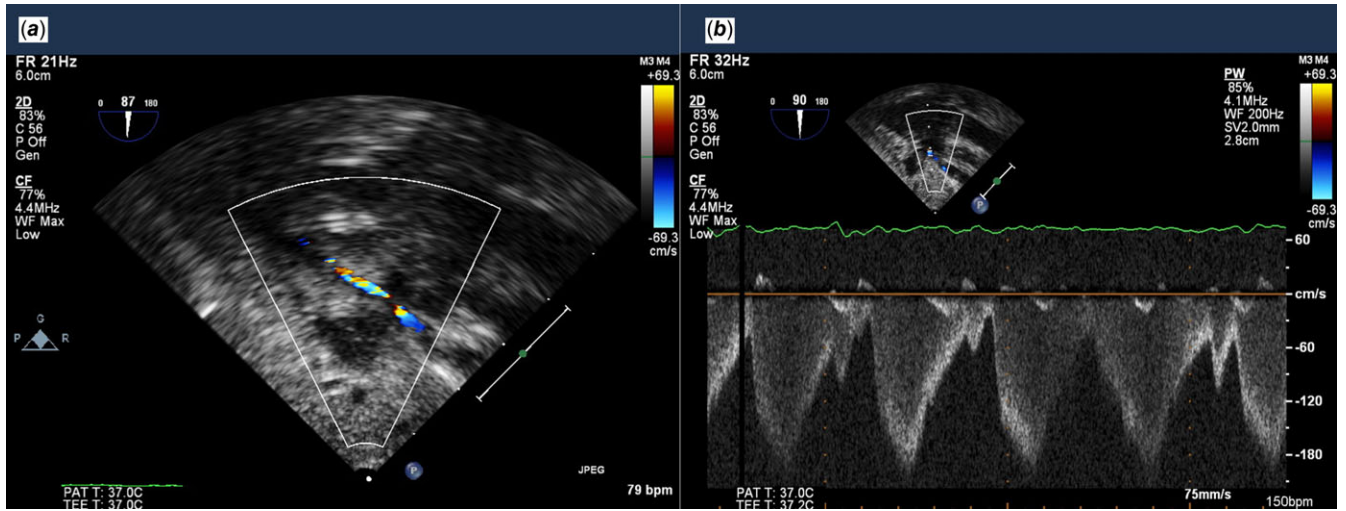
(a) Non-standard transesophageal echocardiography with the probe advanced into the stomach and oriented posteriorly at a 90-degree angle demonstrating severe narrowing of the abdominal aorta with aliasing of flow. (b) Pulsed wave Doppler of flow through the narrowed abdominal aorta demonstrating continuous antegrade flow in an obstructive pattern.
